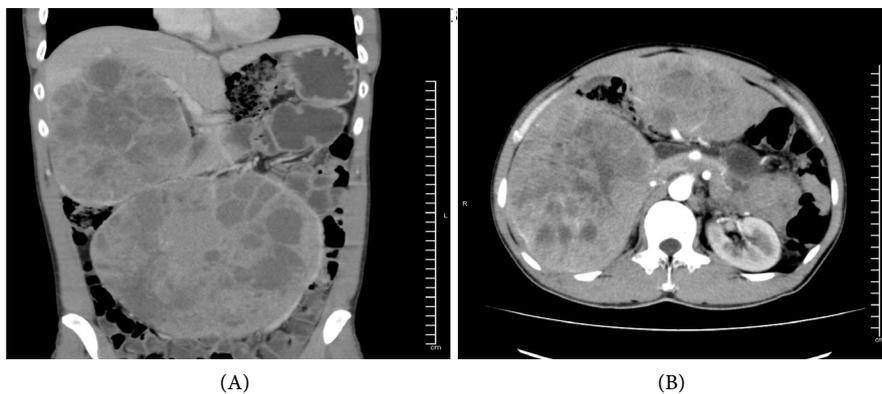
Multidetector computed tomography images. Multiple, well-circumscribed, heterogeneous, and hypodense liver masses are seen. The largest of these is located in the left lobe and measures 203 mm × 92 mm × 232 mm. The background liver tissue is not cirrhotic.
